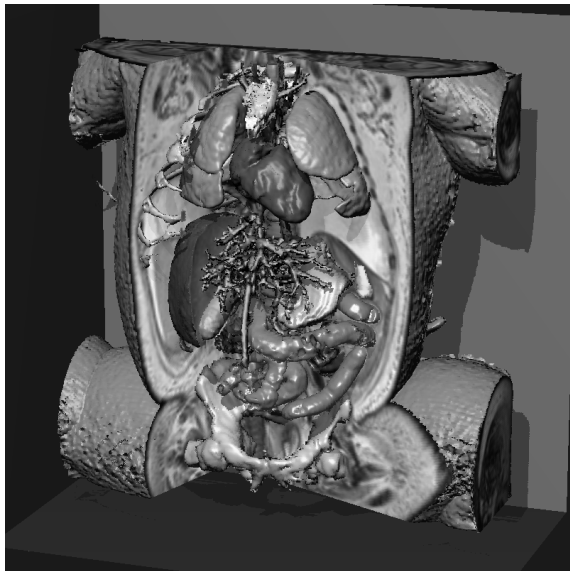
3D image of a still-born fetus from MRI. About 50 objects were defined using an interactive segmentation system.
